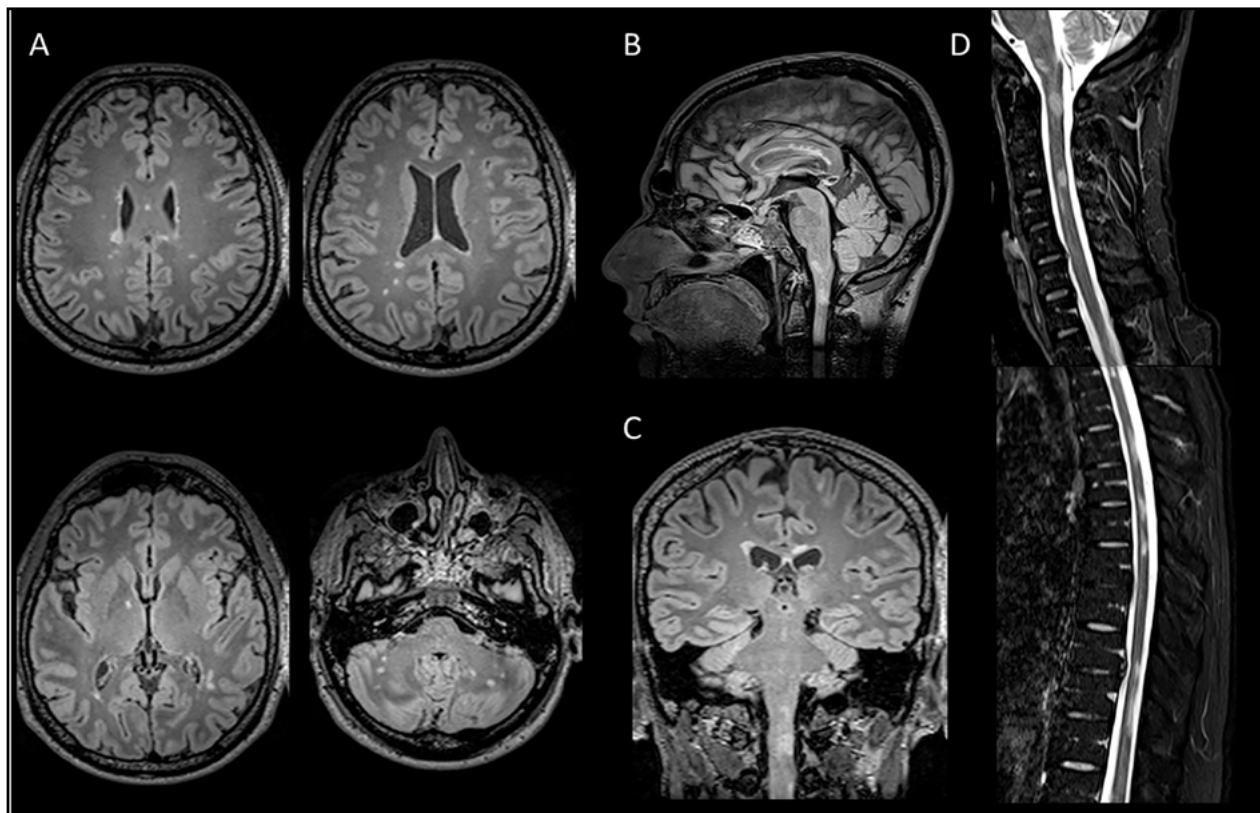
Axial FLAIR images (A) show multiple demyelinating lesions both in the supratentorial and infratentorial white matter. Sagittal (B) and coronal (C) FLAIR sequence depicts corpus callosum and medulla involvement. Sagittal STIR (D) demonstrates several demyelinating lesions of the spinal cord.
